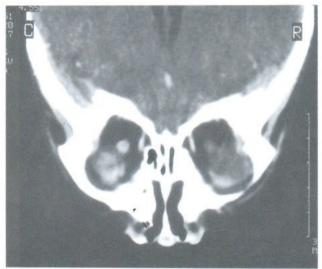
Contrast enhanced CT brain study in coronal plane reveals asymmetrical enlargement, enhancement of the left optic nerve in a case of retinoblastoma left eye which is suggestive of tumor extension along the optic nerve.
